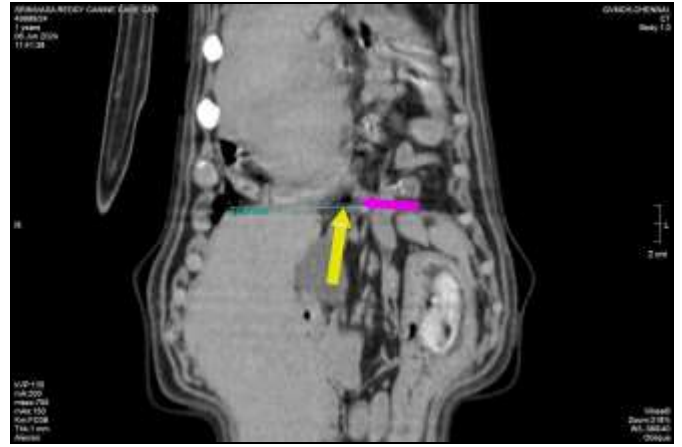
Plain CT - defect in the diaphragm and intestinal loops around the heart
